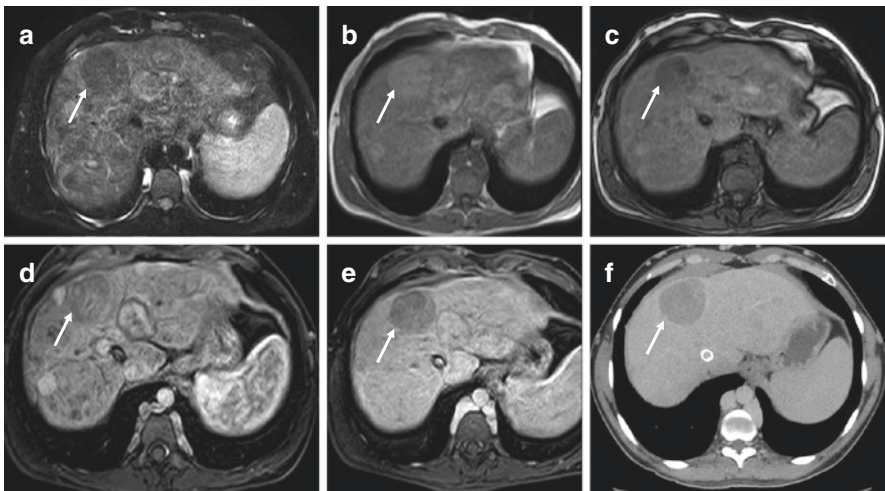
Hepatocellular carcinoma (HCC) in a 24-year-old male patient with chronic Budd–Chiari syndrome secondary to myeloproliferative neoplasm. MRI shows multiples lesions. A nodule in segment 4 shows signal hypointensity on T2-weighted images (a), iso- to hyperintensity on gradient echo in phase T1-weighted images (b), with fat content depicted as signal drop out on opposed phase images (c). After injection of extra-cellular contrast agent, the lesion did not show arterial phase hyperenhancement (d). On portal venous phase the lesions showed marked wash-out (e). Similar aspect was depicted on contrast-enhanced portal venous phase CT images (f). The diagnosis of HCC was confirmed by percutaneous biopsy
